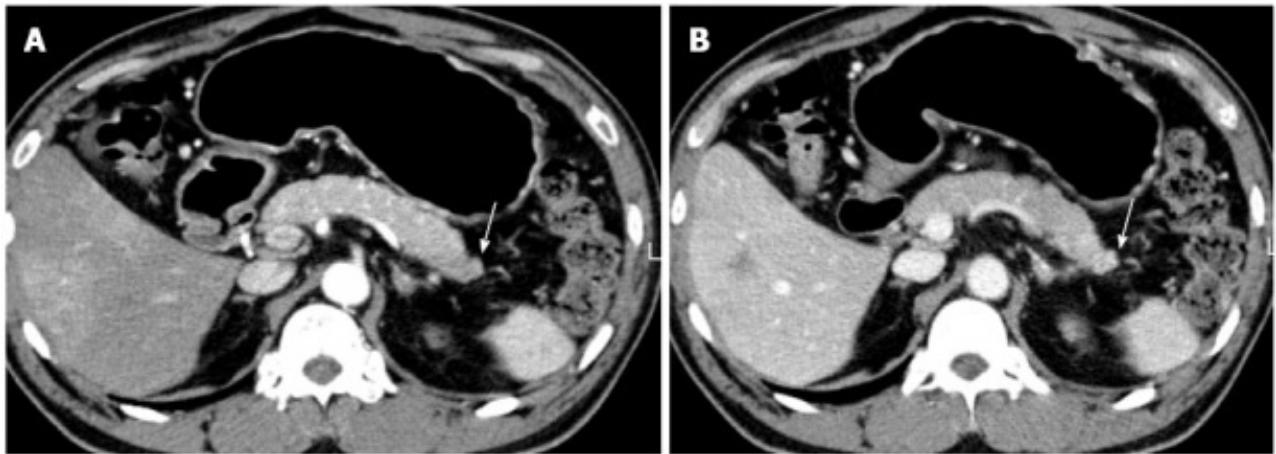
Pancreatic tail mass on Multi-Detector Computed Tomography (MDCT).[26]
